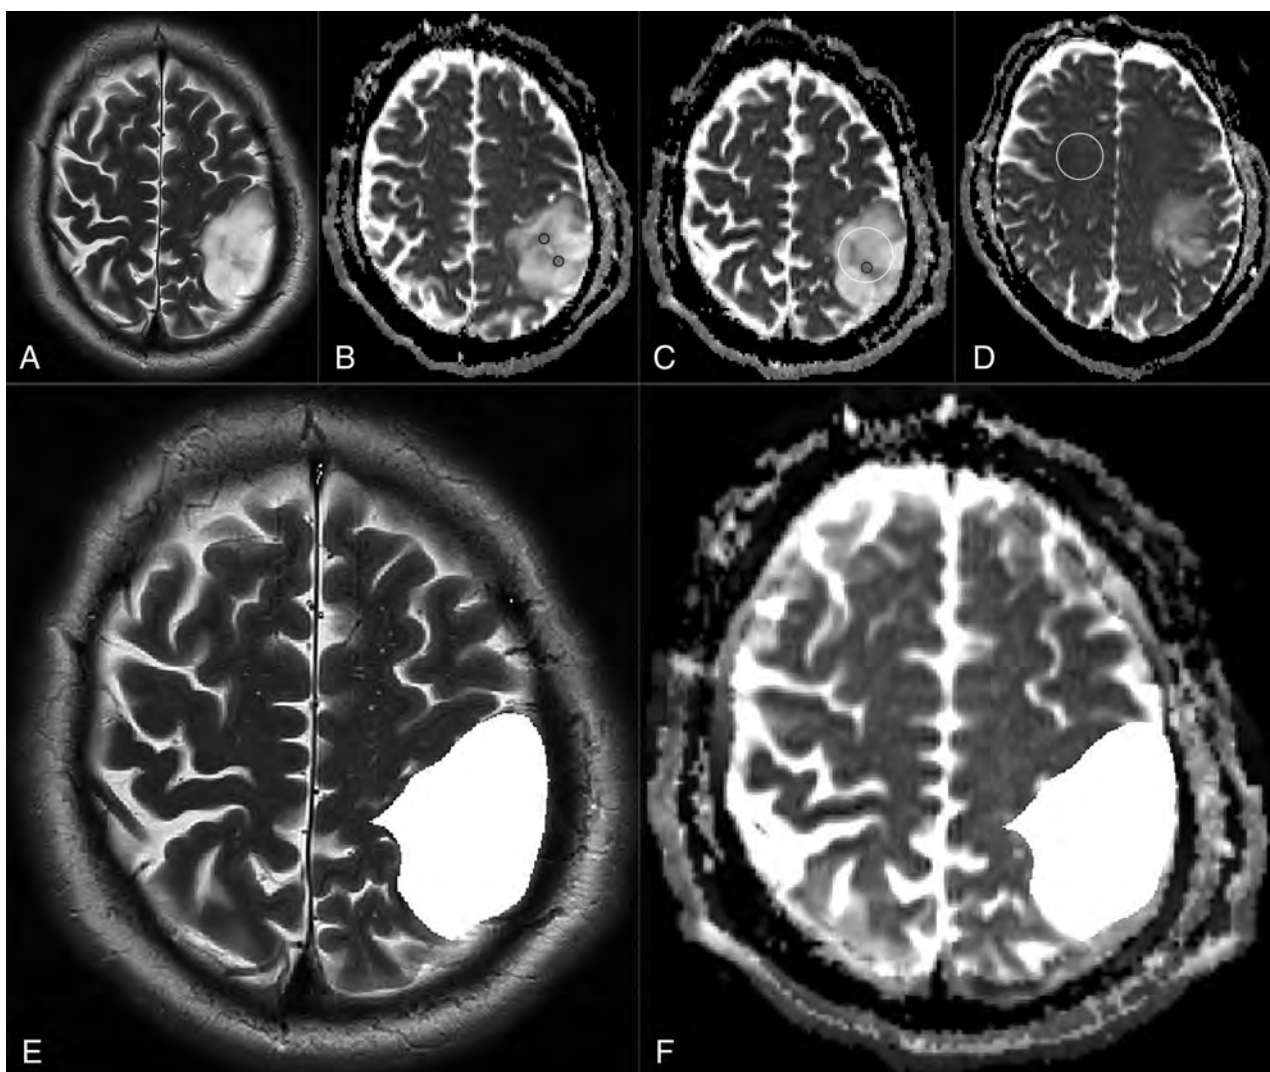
An example of regional and volumetric ADC measurements in a patient with *IDH* mutant 1p19q intact glioma. T2-weighted image (A) and ADC maps (B–D) show ADC_{min} ($3 \times 30\text{--}40\text{ mm}^2$) (black, B and C), ADC_{mean} (white, C), and ADC_{NAWM} (white, D) ROI measurements. T2-weighted image (E) and ADC map (F) in the same patient demonstrate the volumetric segmentation and image registration, respectively.
